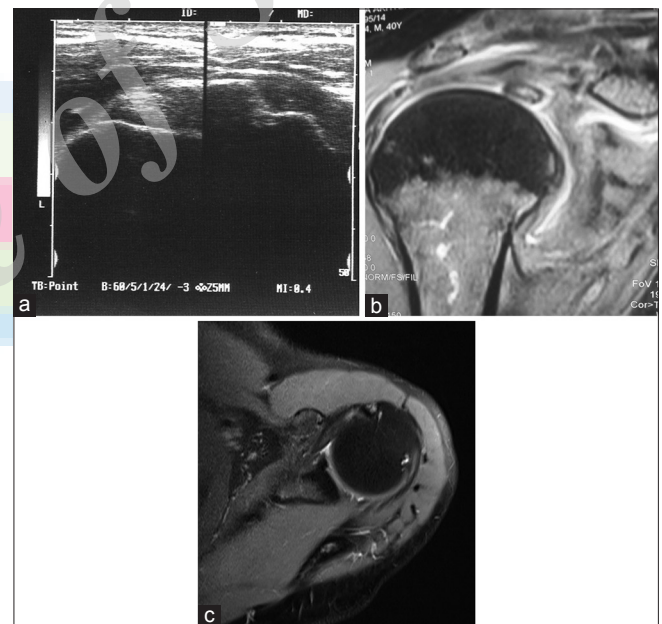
(a) Short-axis ultrasound image showing bulky hypoechoic biceps tendon suggesting tendinopathy. (b and c) Coronal T2-weighted and axial PD-weighted image showing hyperintense signal involving biceps tendon representing tendinopathy
